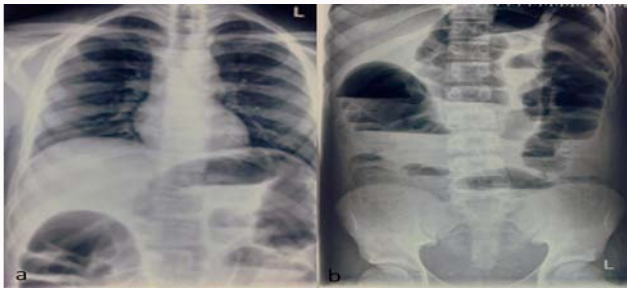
a) Chest X-Ray PA view b) Abdominal X-Ray AP erect view.
